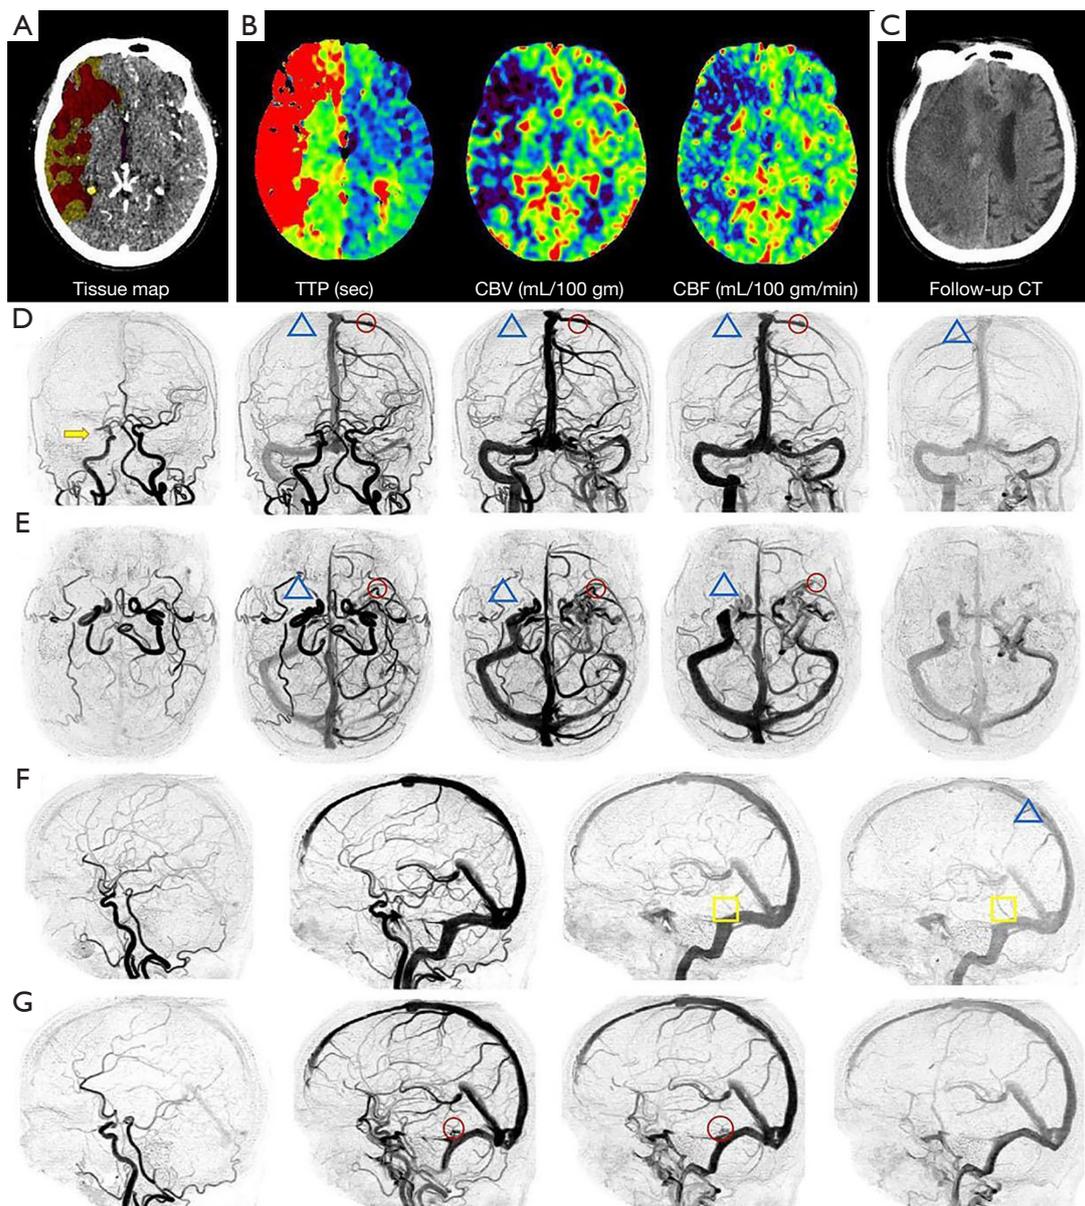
Poor collateral case. An adult patient suddenly fell to the ground. This patient had an initial NIHSS score of 21 and an mRS score of 5 after 3 months. Tissue map showing an IC area (red) of 127.99 mL and an IP area (yellow) of 251.38 mL. (B) CTP (axial 5 mm average registered) showing increased TTP, reduced CBF, and reduced CBV in the MCA territory. (C) The follow-up CT on day 5 showed infarct lesions with hemorrhagic transformation. (D) Coronal plane: 4D CTA showing occlusion of the right MCA (yellow arrow); on delayed phase images, the partial arterial collaterals were developed until the late venous phase. Thus, the patient had an artery collateral score of 1. Partial VOT on the right side (blue triangle) was found in the late venous phase compared with the contralateral VOT (red circle). (E) Axial plane: SMCV and sphenoparietal sinus on the right side (blue triangle) are absent compared with the contralateral side (red circle). (F) Sagittal plane (ischemic hemisphere): partial VOL (yellow quadrangle) and partial VOT (blue triangle) were found in the late venous phase. (G) Sagittal plane (non-ischemic hemisphere): full VOL was found on the left side (red circle). Thus, the total 4D-VCS score was 2. TTP, time to peak; CBV, cerebral blood volume; CBF, cerebral blood flow; CT, computed tomography; NIHSS, National Institutes of Health Stroke Scale; mRS, modified Rankin Scale; IC, ischemic core; IP, ischemic penumbra; CTP, computed tomography perfusion; FIV, final infarct volume; 4D CTA: 4D computed tomography angiography; MCA, middle cerebral artery; VOT, vein of Trolard; SMCV, superficial middle cerebral vein; VOL, vein of Labbé; 4D-VCS, cortical venous collateral score based on 4D CTA.
